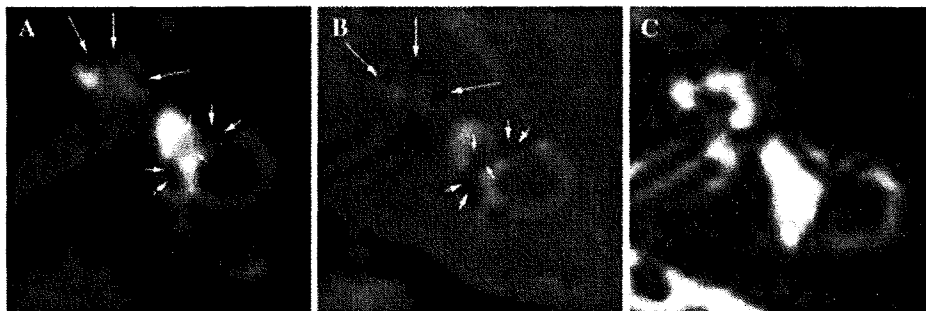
MRI of case 5. a 3D FLAIR shows enlarged endolymphatic space in the cochlea (*arrows*) as low signal areas. However, the boundary between the endolymphatic space and surrounding bone is unclear. Moderate enlargement of the endolymphatic space in the vestibule (*short arrows*) was observed. b A 3D-real IR sequence visualizes
